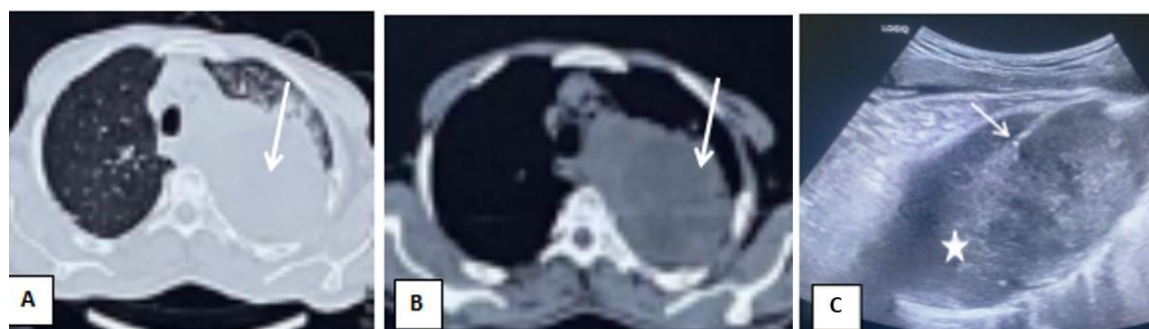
(A) CT lung window. (B) Mediastinal windows show left upper lobe apical-posterior segment peripheral subpleural masses (arrow). (C) TUS low frequency convex probe B-mode image shows heterogeneous hypochoic lesion (star). Tru-cut needle (arrow) is seen within the lesion.
